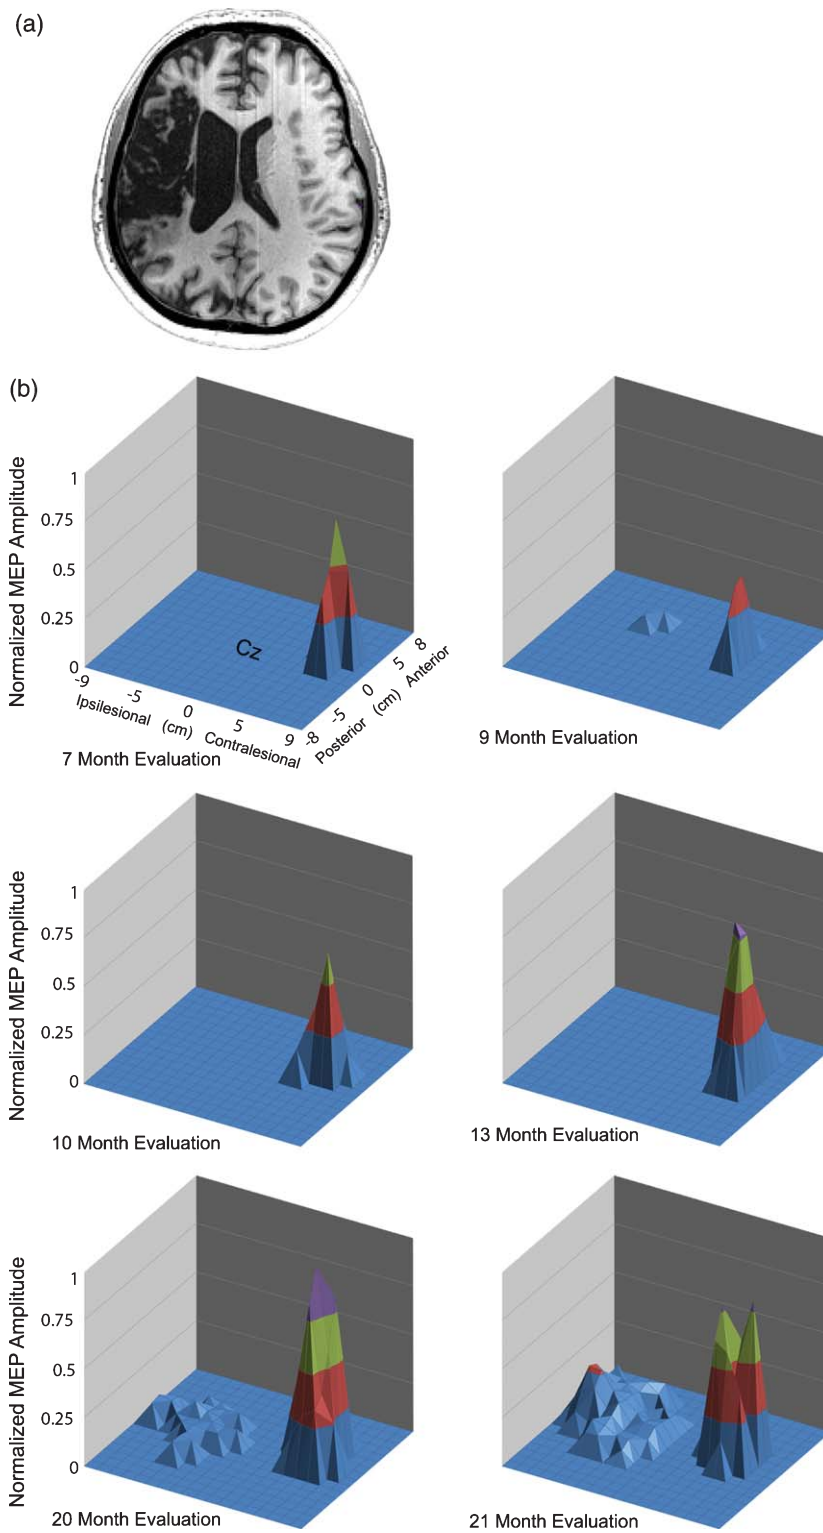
(a) Axial view of T1 weighted MRI displayed in neurological convention. (b) TMS motor maps: change over time. X- and y-coordinates indicate scalp position; z-axis indicates normalized MEP amplitude.
